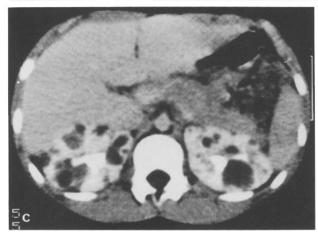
Children with DPKD. a IVP of patient 8 A at 1 year of age is normal. b US of the same patient at the same age shows slightly increased echogenicity, unsharp contour and cysts of about 1.0 cm in diameter. c CT of patient 6 B at 11 years shows cortical and medulary cysts and evenly distributed contrast medium
